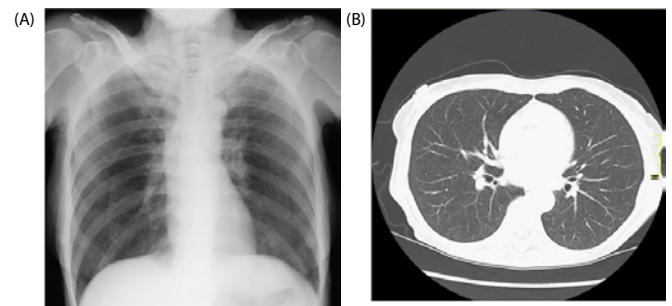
No normal findings on the chest X-ray or on chest CT (A and B).
